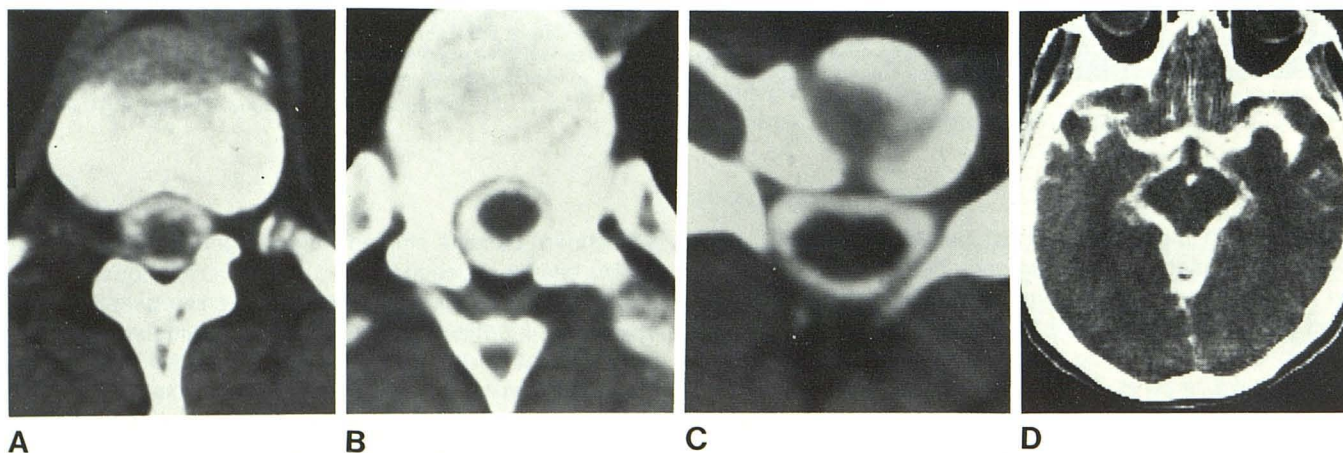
Normal lopamidol CT myelography and cisternography. Normal conus medullaris (A), thoracic cord (B), cervical cord (C), and midbrain (D), which is highlighted by lopamidol in interpeduncular, crural, and ambient cisterns. These scans were obtained after lumbosacral myelography with no deliberate attempt to fill thoracic, cervical, or intracranial subarachnoid spaces.
